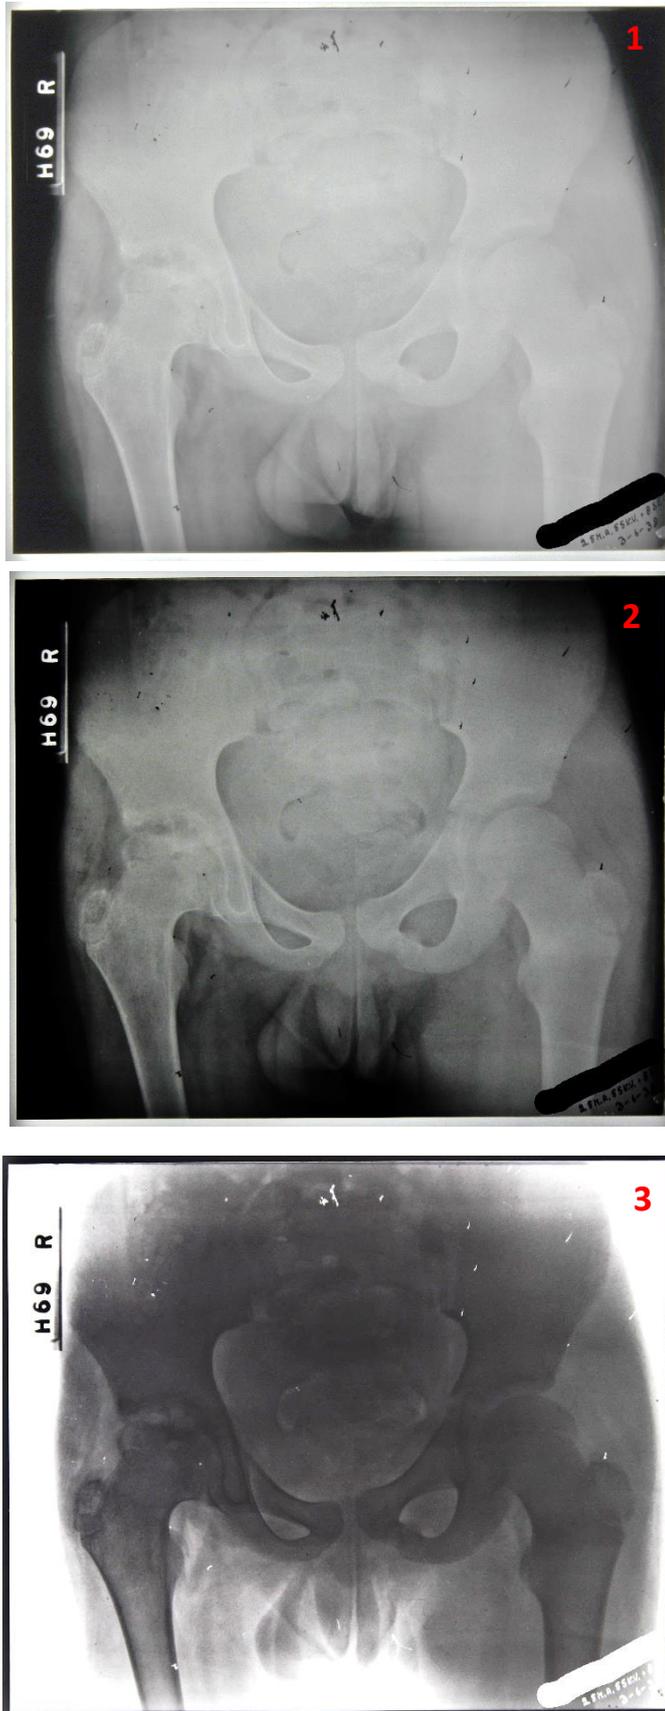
Three radiographs demonstrating digital image processing used in the analysis of the Stannington Sanatorium radiographs. 1. Original image with no digital enhancement shows under-exposure with limited view of pathology in the right hip. 2. Altered contrast and brightness, shows clearer outlines and detail of infected area. 3. Inverted image with slight contrast, shows anatomical sites affected and pathology of the acetabulum and femoral epiphysis (HOSP/STAN/7/1/2/60_09)
